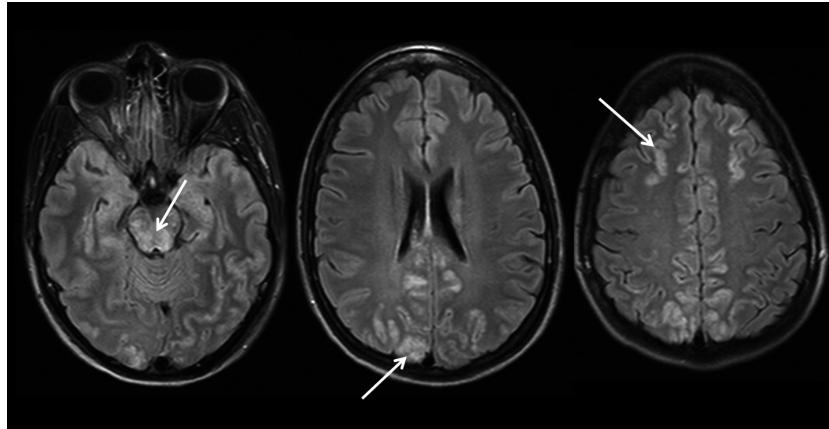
Magnetic resonance imaging with T2-flair-weighted images showing the typically hyperintense bilateral lesions indicating vasogenic edema in the parietooccipital regions as well as less common lesions in the frontal regions and brain stem (arrows).
